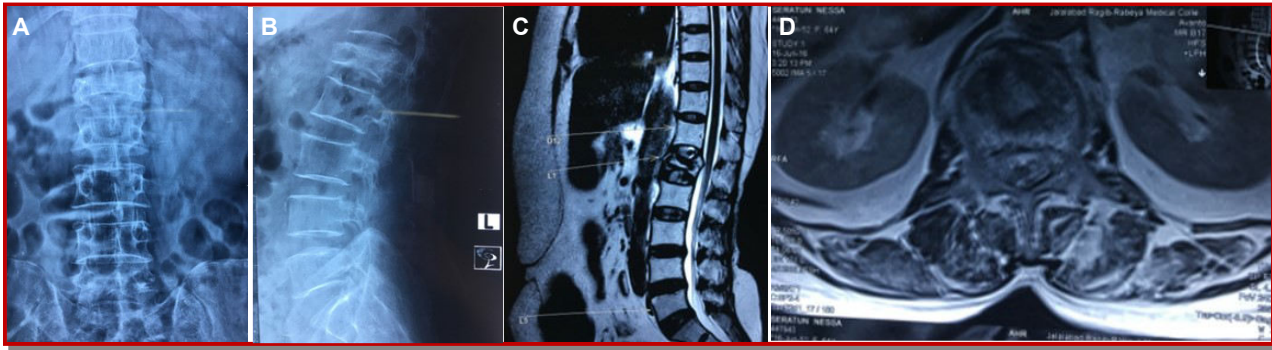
X-ray showing vertebral compression fracture at D11 AP (A) and lateral (B) view; MRI showing sagittal (C) and axial (D) view of vertebral compression fracture at D11
